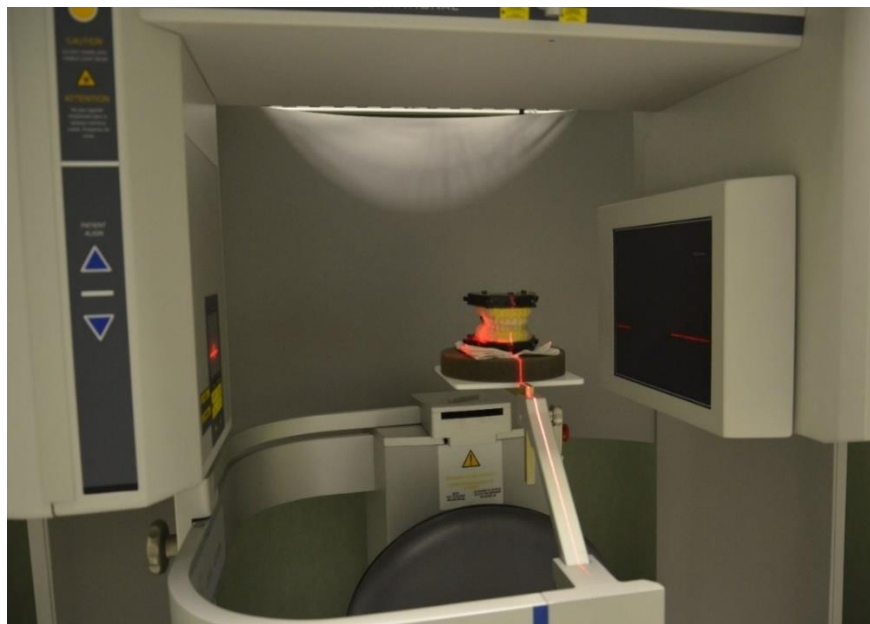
i-CAT® Imaging Cone Beam next generation CT system, showing the alignment light guides.
